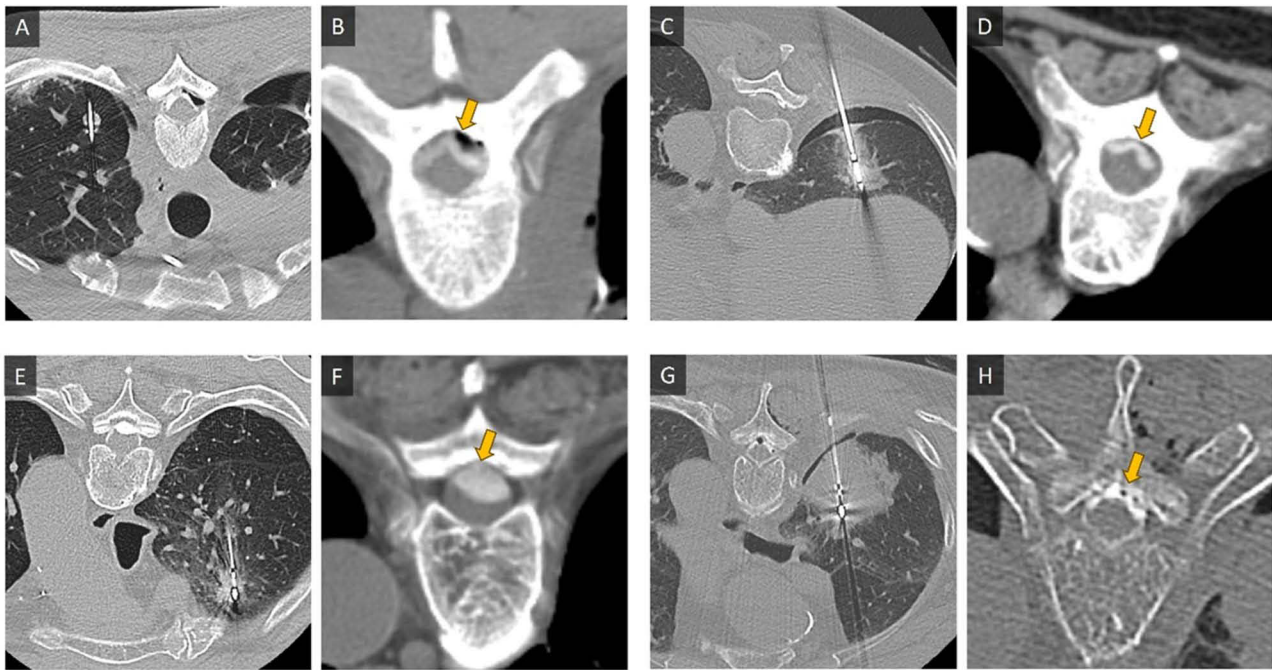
Representative computed tomography images of dural puncture. (A and B) Computed tomography images of a 55-year-old man who had undergone microwave ablation for left upper lobe lung metastatic tumor. (B) Axial imaging at T8 level showed contrast medium and air in the subdural space with inverted Mercedes-Benz sign (arrow), indicating a traumatic dural puncture. Tiny air bubbles in the epidural space was also depicted. The patient had post dural puncture headache and the symptom improved after conservative treatment. (C and D) Computed tomography images of a 72-year-old man with synchronous multifocal lung adenocarcinoma who had undergone microwave ablation for enlarged right lower lobe lung tumor. (D) Axial imaging at T6 level showed contrast medium in the subdural space with inverted Mercedes-Benz sign (arrow), indicating a traumatic dural puncture. The patient was asymptomatic. (E and F) Computed tomography images of a 80-year-old man who had undergone microwave ablation for right upper lobe metastatic tumor. (F) Axial imaging at T3 level showed contrast medium in the subdural space, indicating a traumatic dural puncture (arrow). And the spinal cord was compressed. However, the patient was asymptomatic. (G and H) Computed tomography images of a 80-year-old women with right lower lobe squamous cell carcinoma post video-assisted thoracoscopic surgery right lower lobe wedge resection who had undergone microwave ablation for right lower lobe recurrent tumor. (H) Axial imaging at T4 level showed contrast medium and air in the epidural space (arrow), confirming the absence of dural puncture.
